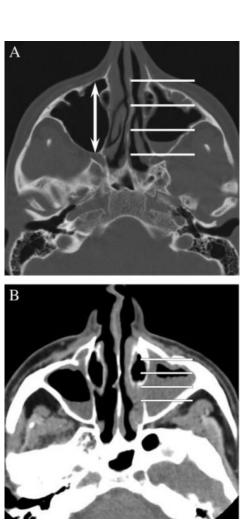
Categorization of amount of sinus fluid. (A) On axial CT images, the antero-posterior dimension of the sinus (double arrow) was divided into thirds (horizontal lines). The amount of fluid in the sinus was categorized as: no fluid, <1/3 fluid-filled, 1/3 to 2/3 fluid-filled, or >2/3 fluid-filled. In this example, the amount of fluid in the left maxillary sinus would be <1/3. (B) If mucosal disease was present, the antero-posterior measurement excluded the mucosal thickening. Only the potentially aerated portions of the sinus were divided into thirds (horizontal lines). Note that the posterior mucosal thickness must be estimated. In this example, the left maxillary sinus is 1/3-2/3 filled.
